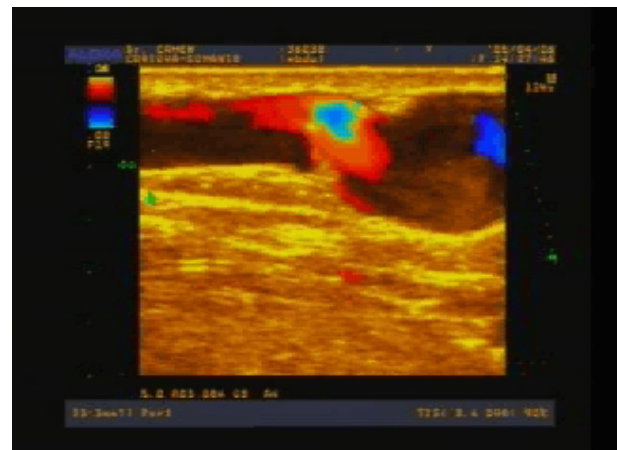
Eccentric reflux with secondary eccentric subvalvular dilatation (echo Doppler).
